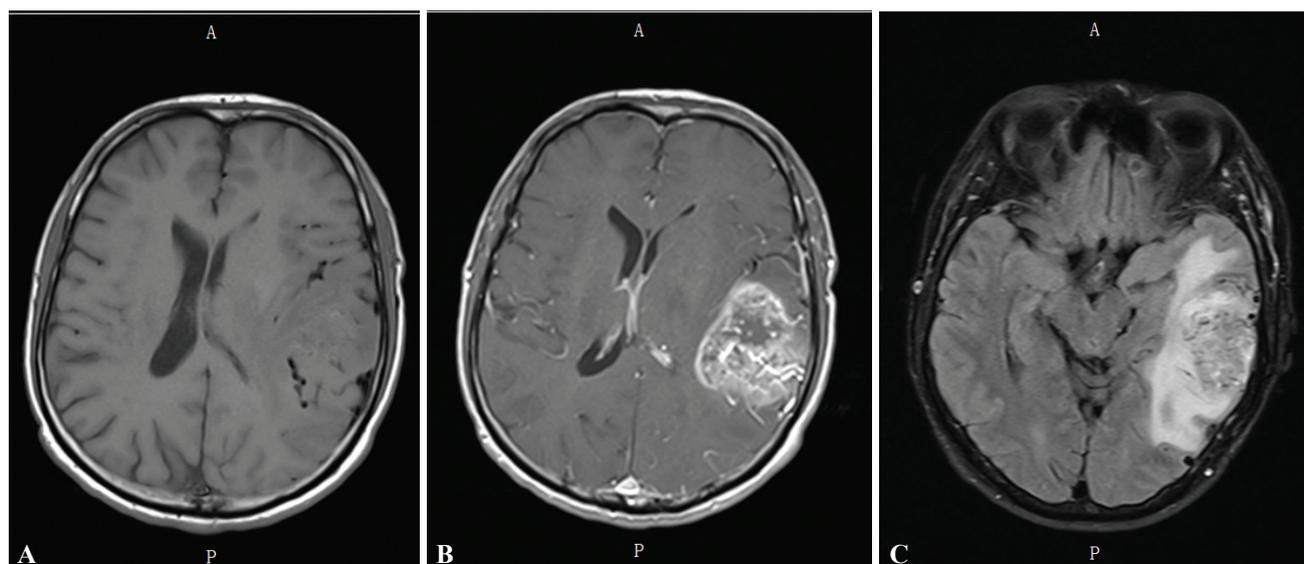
Glioblastoma in the left temporal lobe in a 51-year-old man. (A) Axial pre-contrast T1WI revealing hypointense lesion in the left temporal lobe. (B) Axial FLAIR image reveals a heterogeneous lesion in the left temporal lobe. (C) Axial post-contrast T1WI revealing irregular enhancement in the left temporal lobe.
